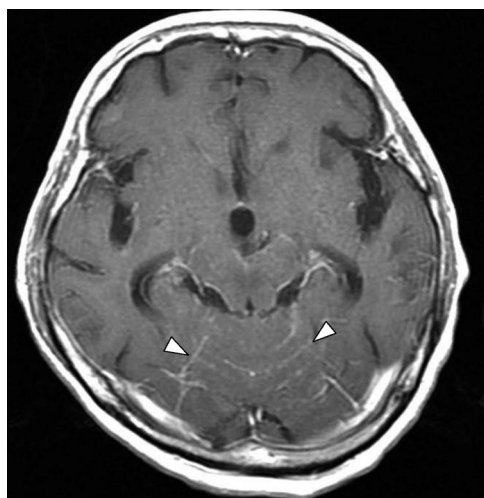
The magnetic resonance image shows findings of leptomeningeal metastases (arrow heads).
